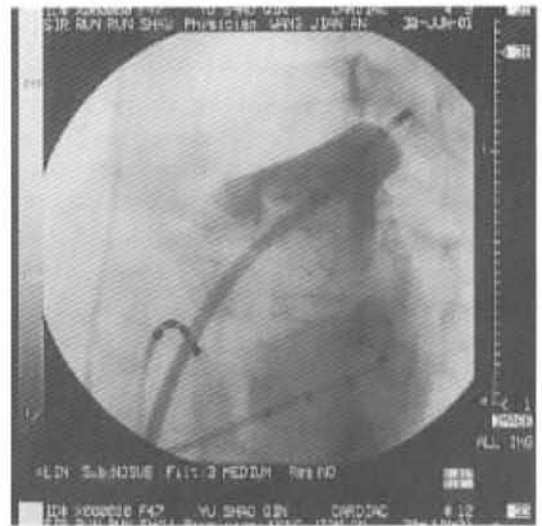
Ultrasound balloon is inflated in the ostium of the left superior pulmonary vein. Angiography shows no contrast into the main branch of the vein because the inflated balloon blocks the ostium of the vein
